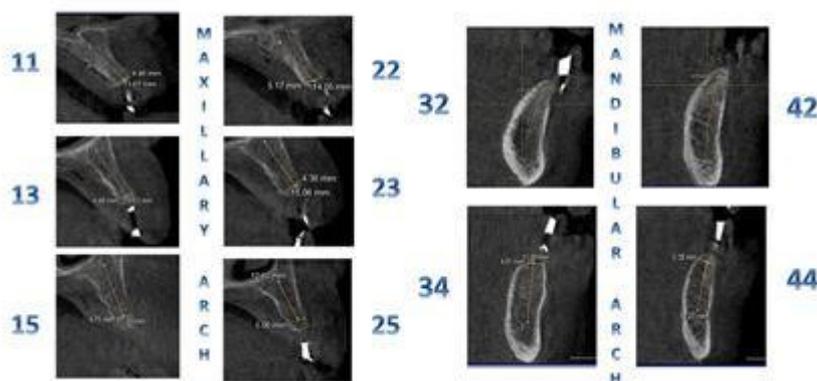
CBCT cross sections of each tooth panned for implant placement in maxillary and mandibular arches. The complete blood report was done and being a known diabetic, the patient was referred to for a physician's consent for any surgical procedure.
